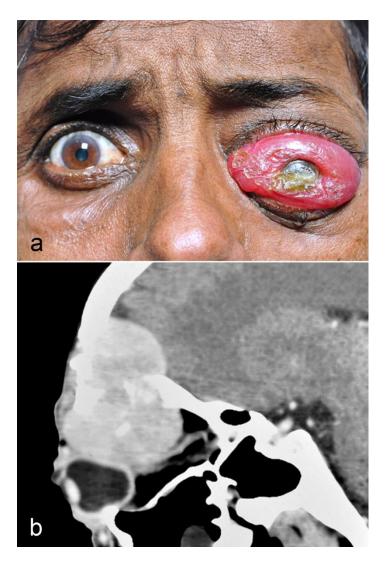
External photograph of the patient showing gross proptosis of the left eye with severe conjunctival chemosis (Fig 3a). CT scan with saggital reconstruction showing a large mass lesion in the superior orbit with extension into the frontal sinus and intracranial space (Fig 3b).
